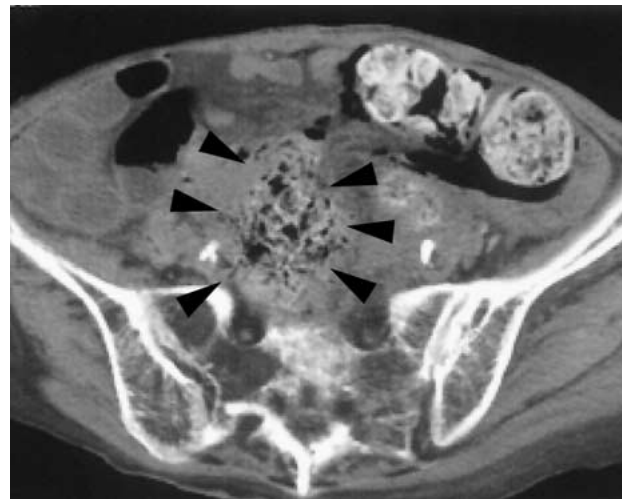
Contrast-enhanced CT image of spontaneous perforation of the sigmoid colon (the same patient as shown in Fig. 1). Perforated extraluminal feces display a unique appearance of a mass with mottled radiolucence in the pelvis (arrowheads).
